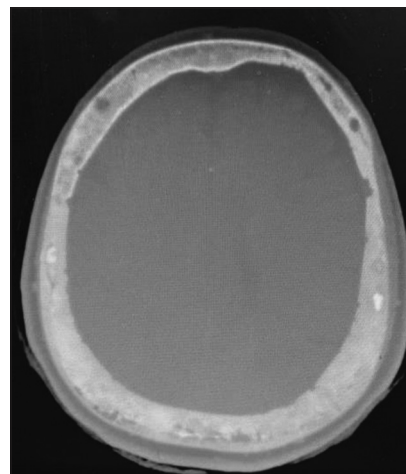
Computed tomography scan of the brain without contrast, showing expanded bones of the skull with multiple sclerotic and lytic lesions.
